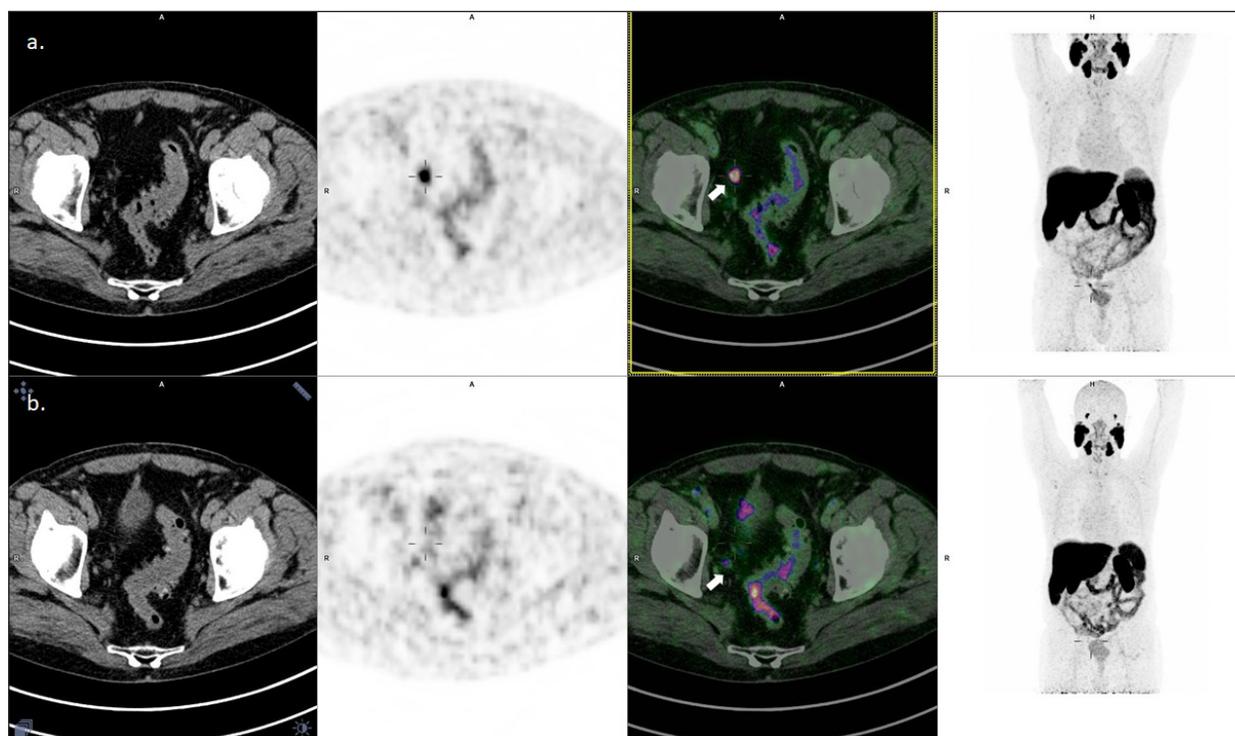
Gallium-68-prostate-specific membrane antigen (^{68}Ga -PSMA) positron emission tomography (PET)/computed tomography (CT) of a 68-year-old patient with rising PSA value. A. Axial CT showing thickening of right vas deferens (VD) compared to the contralateral. PET imaging showing intense uptake. Axial CT fused with PET showing anatomical correspondence of the uptake (the red arrow head indicates the pathological uptake); B. ^{68}Ga -PSMA PET/CT at the last follow-up showing complete metabolic response to treatment. Axial image, PET alone and fused images are shown. The red arrow head indicate residual VD with no uptake
